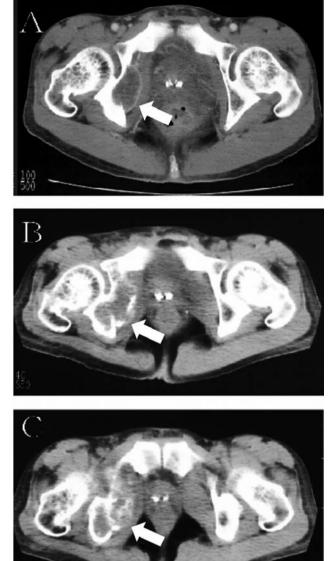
Computed tomography (CT) of pelvic bone metastasis (arrows): before vaccination (A), 4 months after vaccination (B), 8 months after vaccination (C). Note the increase in calcification of the pelvic tumor at lower left of each CT scan (B and C).
